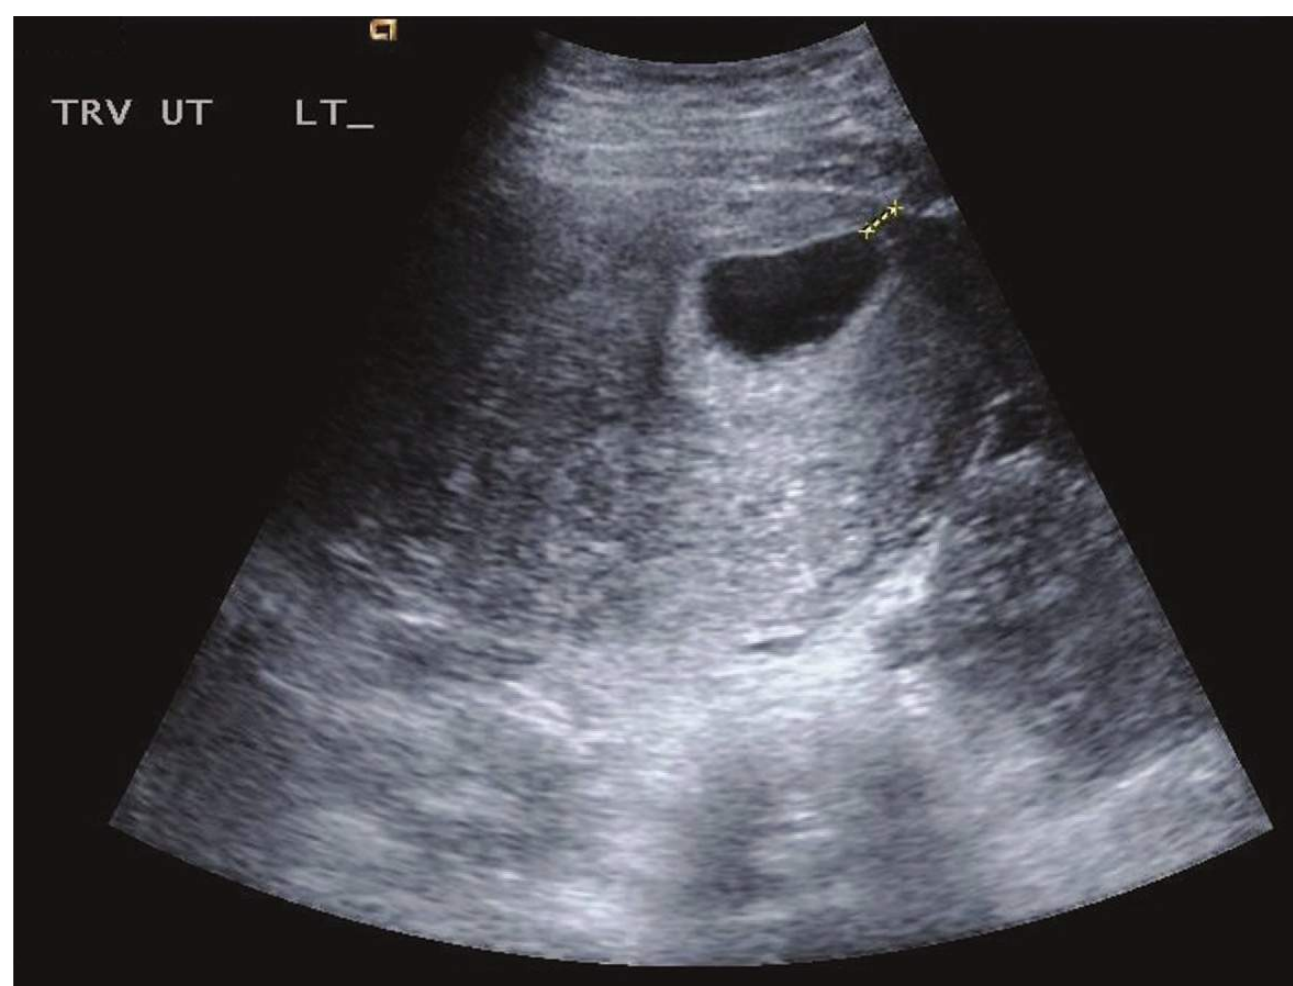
■ Interstitial Ectopic. An interstitial ectopic exists when the gestational sac is less than 5 mm away from the uterine wall. This formal ultrasound confirmed a bicornate uterus and viable pregnancy with a distance 6.1 mm, enough endometrium to support normal pregnancy. (Photo contributor: Lauren Oliveira, DO.)
